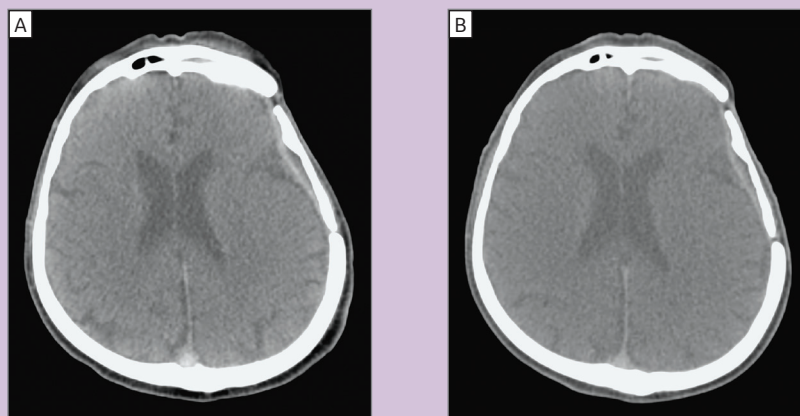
(A) CT from TOF system and (B) CT from Discovery IQ 5-Ring system.
